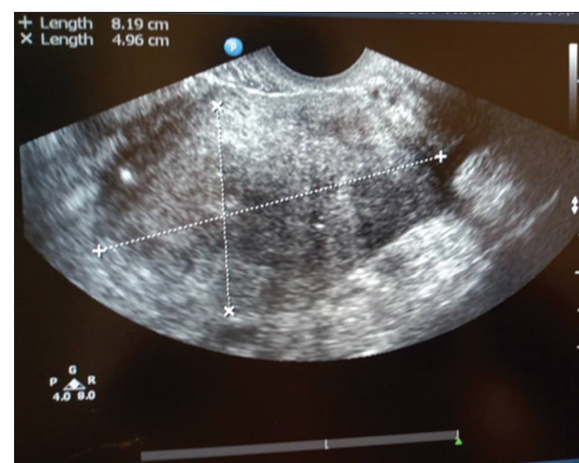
A Transvaginal ultrasound scan (USS) image showing the Uterus measured in length and Anterior – Posterior diameter
